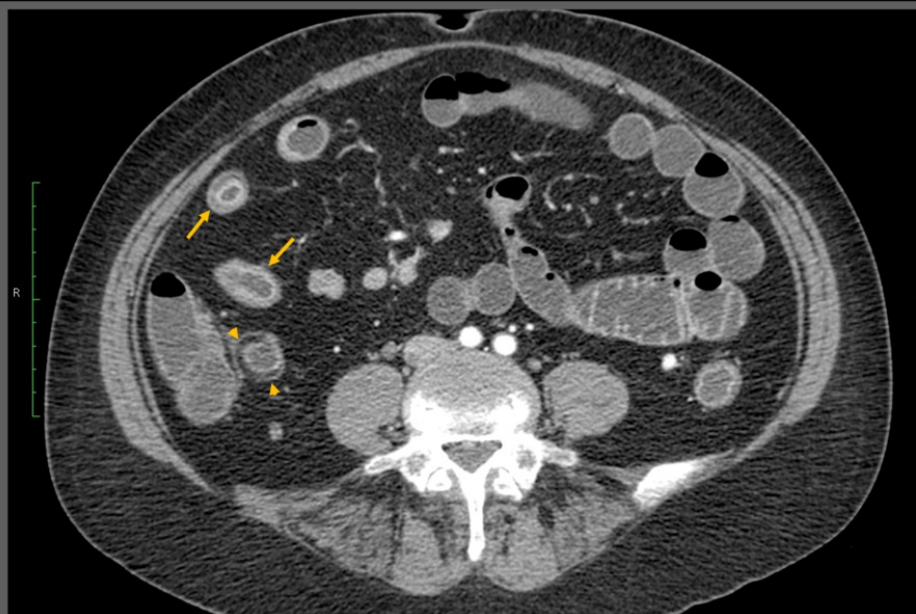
Mural stratification. Axial CT enterography section demonstrates mucosal thickening and hyperenhancement as well as submucosal edema indicative of active disease (arrows). Submucosal fat deposition due to chronic disease is also present. (arrowheads).
